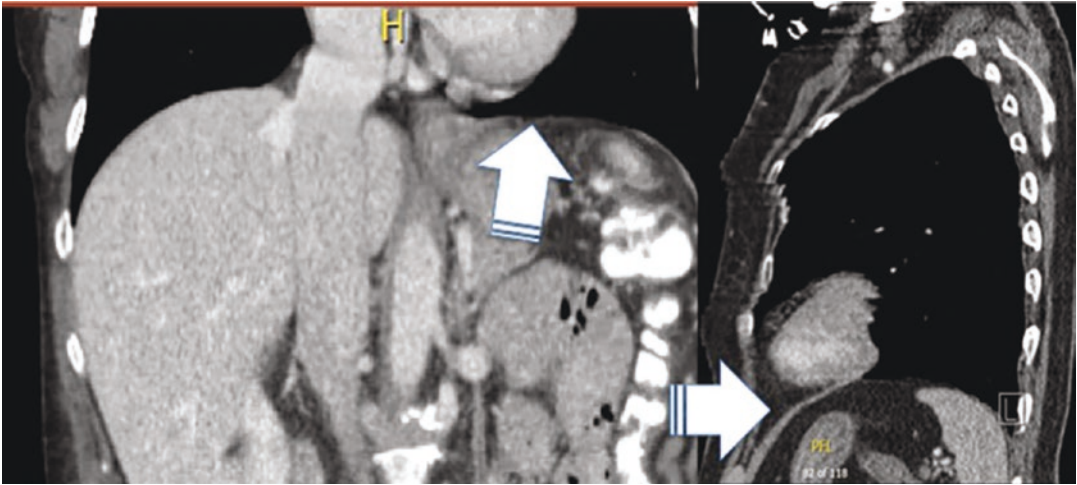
Normal coronal and sagittal CT appearance of the diaphragm (arrows)
